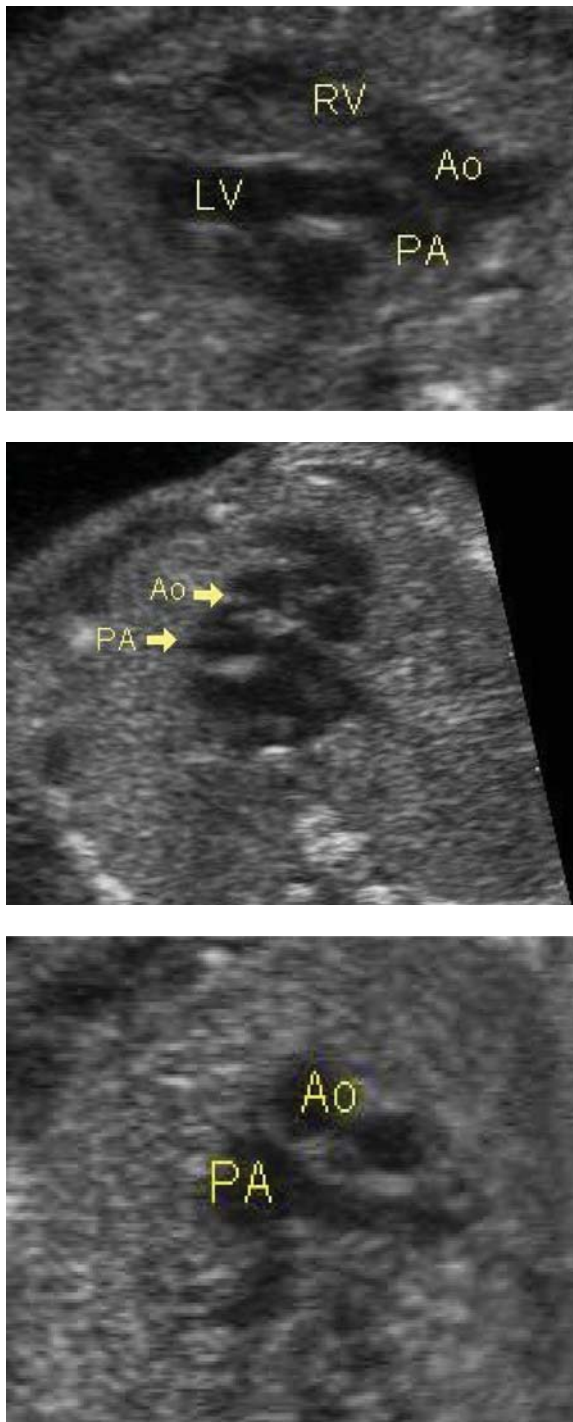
Echocardiography at 21 weeks in a fetus with transposition. Note the parallel course of the aorta (Ao) arising from the right ventricle (RV), and the pulmonary trunk (PA) arising from the left ventricle (LV) (upper panel). In cross sectional view, the aorta is seen anterior to the pulmonary trunk (middle and lower panels).
